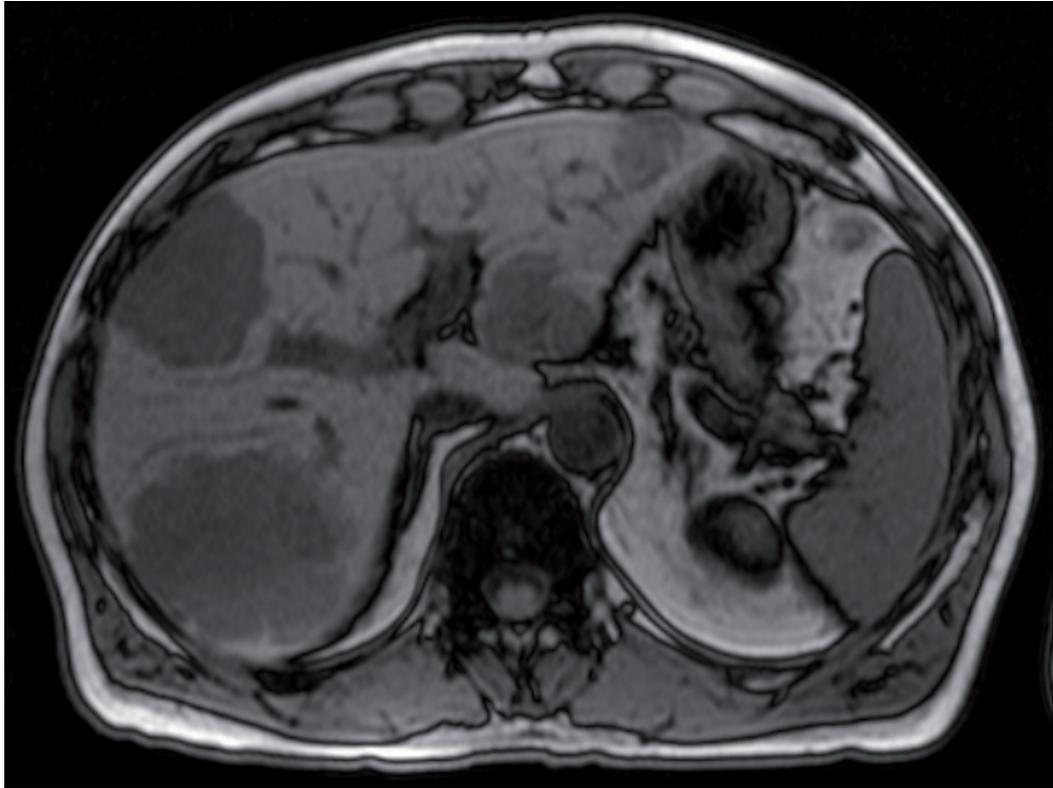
Typical MRI scan of patient with bilobar disease who would be considered suitable for a two staged approach to liver resection. With this distribution of disease a one stage approach would not leave an adequate FLR.
